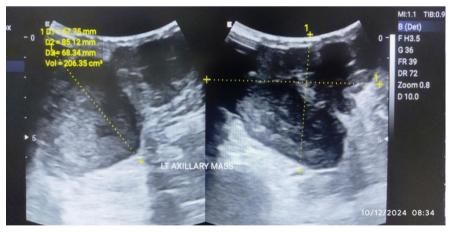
Ultrasonography image showing huge mass with lobulated borders and internal cystic clefts with an approximate size of $10.0 \times 9.0 \times 9.0$
